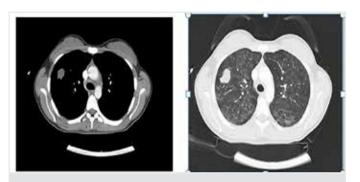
Tharax computed tomography image
